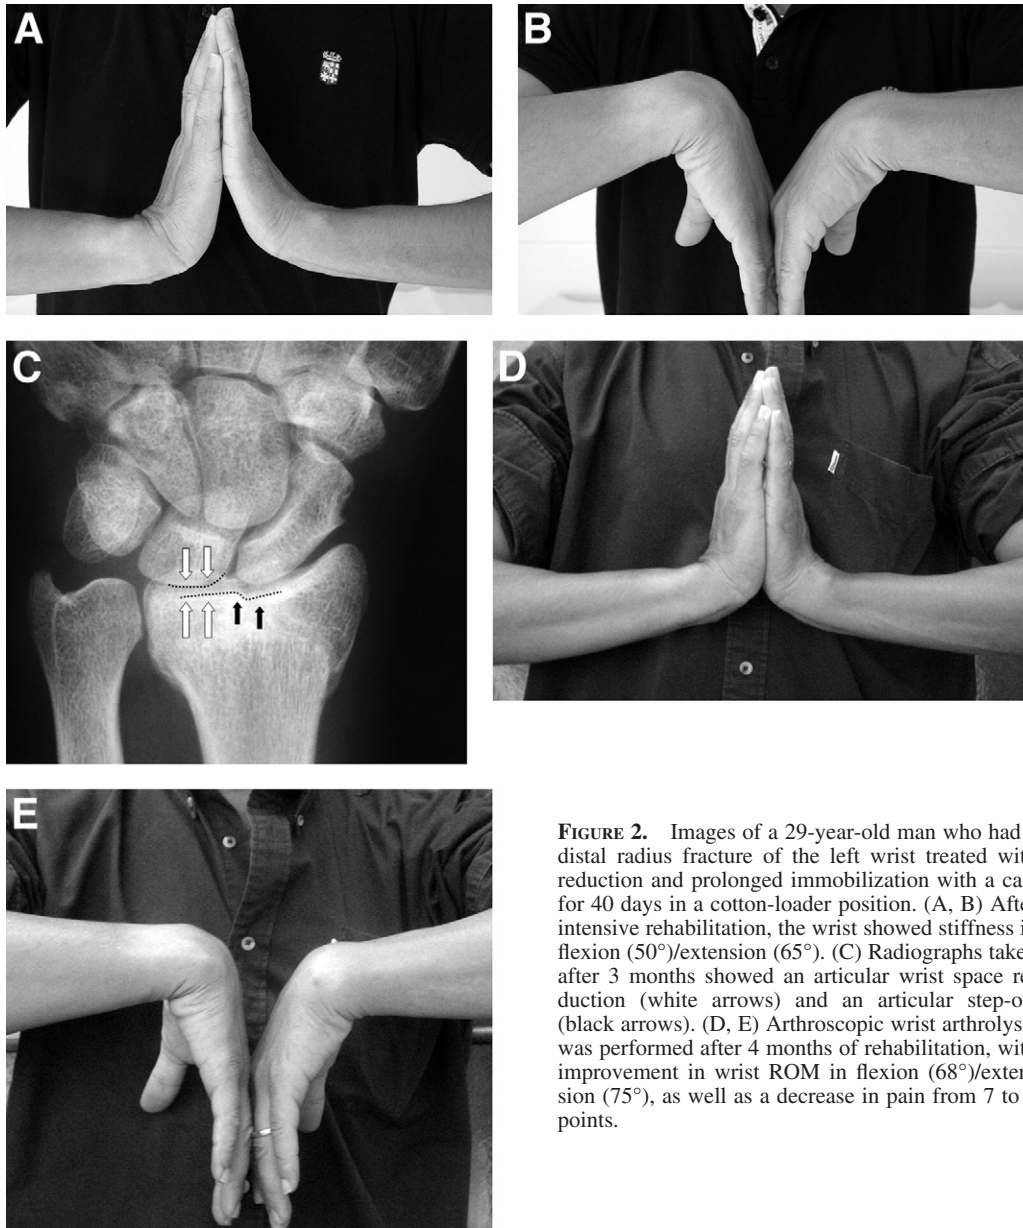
Images of a 29-year-old man who had a distal radius fracture of the left wrist treated with reduction and prolonged immobilization with a cast for 40 days in a cotton-loader position. (A, B) After intensive rehabilitation, the wrist showed stiffness in flexion (50°)/extension (65°). (C) Radiographs taken after 3 months showed an articular wrist space reduction (white arrows) and an articular step-off (black arrows). (D, E) Arthroscopic wrist arthrolysis was performed after 4 months of rehabilitation, with improvement in wrist ROM in flexion (68°)/extension (75°), as well as a decrease in pain from 7 to 1 points.
